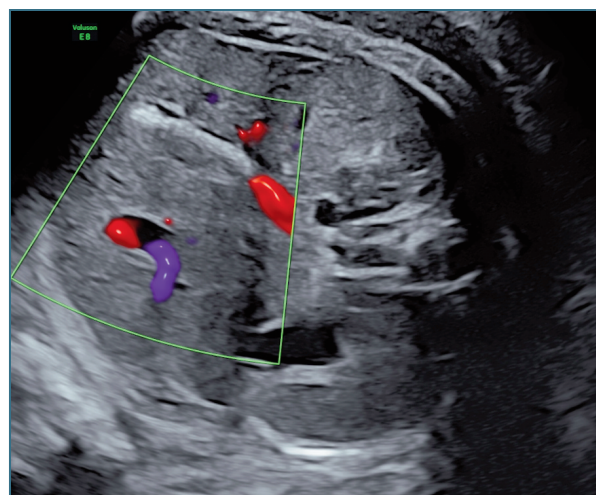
Distended gallbladder filled with hyperechogenic fluid, no vascularization on color doppler.
